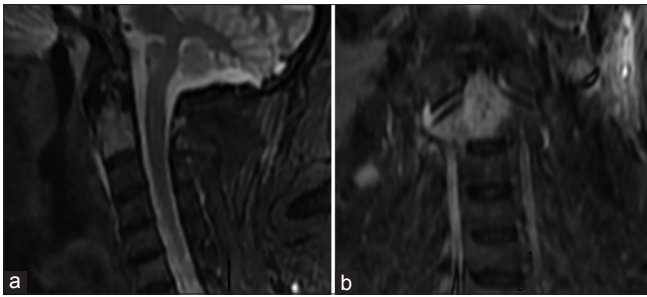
Magnetic resonance imaging cervical spine with contrast showing a contrast enhancing lesion involving the body and dens of C2 (a) sagittal (b) coronal image
